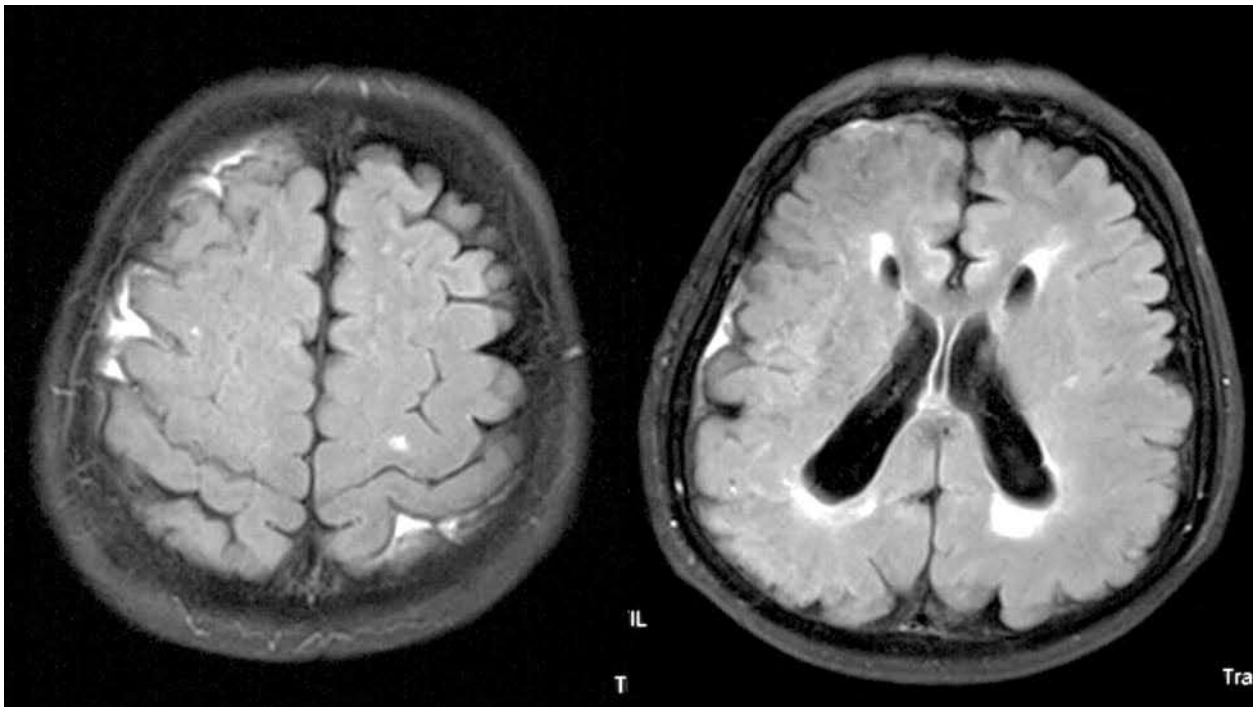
MRI flair sequence in axial plane shows subarachnoid hemorrhage and ischemic lesions bilaterally.
